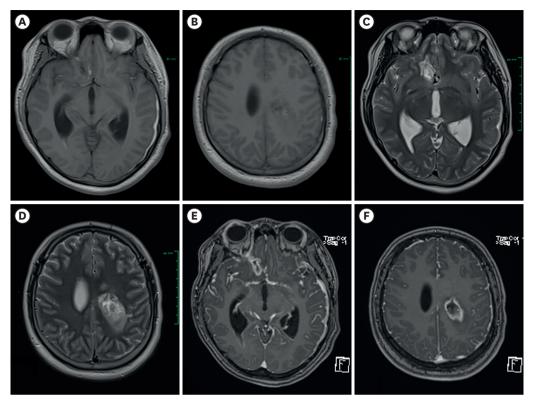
Contrast-enhanced magnetic resonance imaging showing leptomeningeal enhancement suggestive of meningitis. (A, B) T1-weighted images show hemorrhage with intermediate signal intensity. (C, D) T2-weighted images show hemorrhage with high signal intensity. (E, F) Leptomeningeal enhancement is observed in T1-weighted images with contrast.
